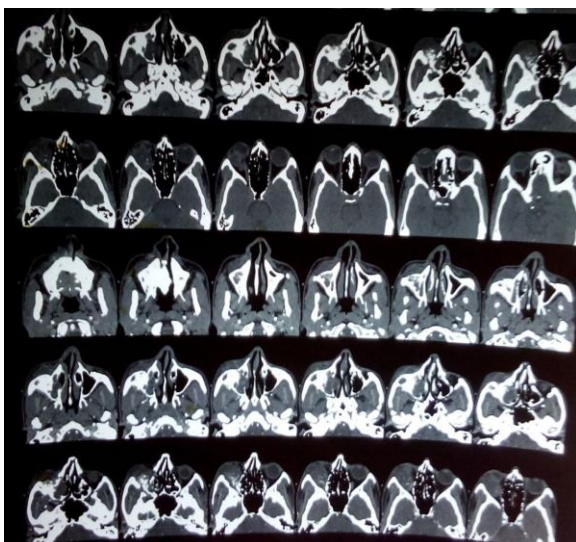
CT scan head and PNS study. Cortical destruction with sunburst reaction involving the walls of maxillary sinus associated with soft tissue component with intraorbital extension
